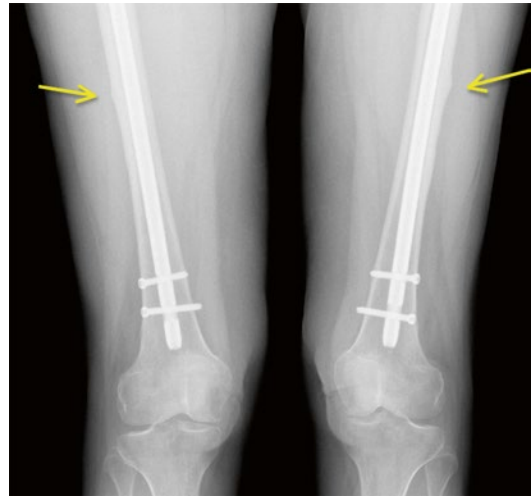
Anteroposterior radiograph demonstrating intramedullary nailing of symptomatic bilateral atypical femur fractures with lateral cortical beaking noted on tension side of femoral shaft (arrows)
